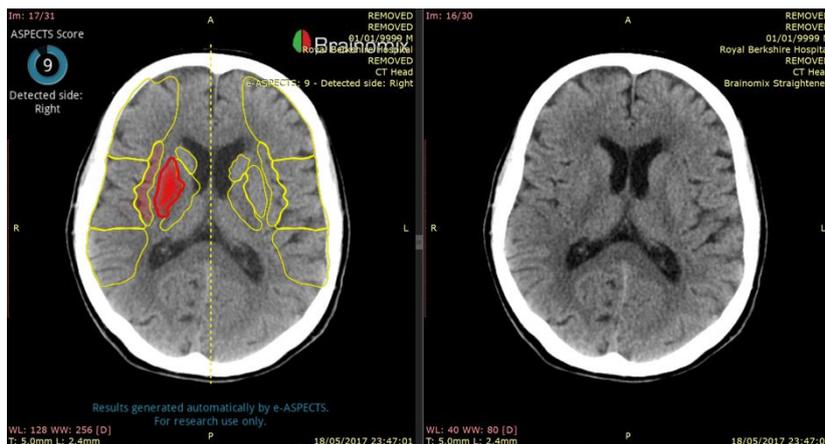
An example of an e-ASPECTS output on a PACS viewer
